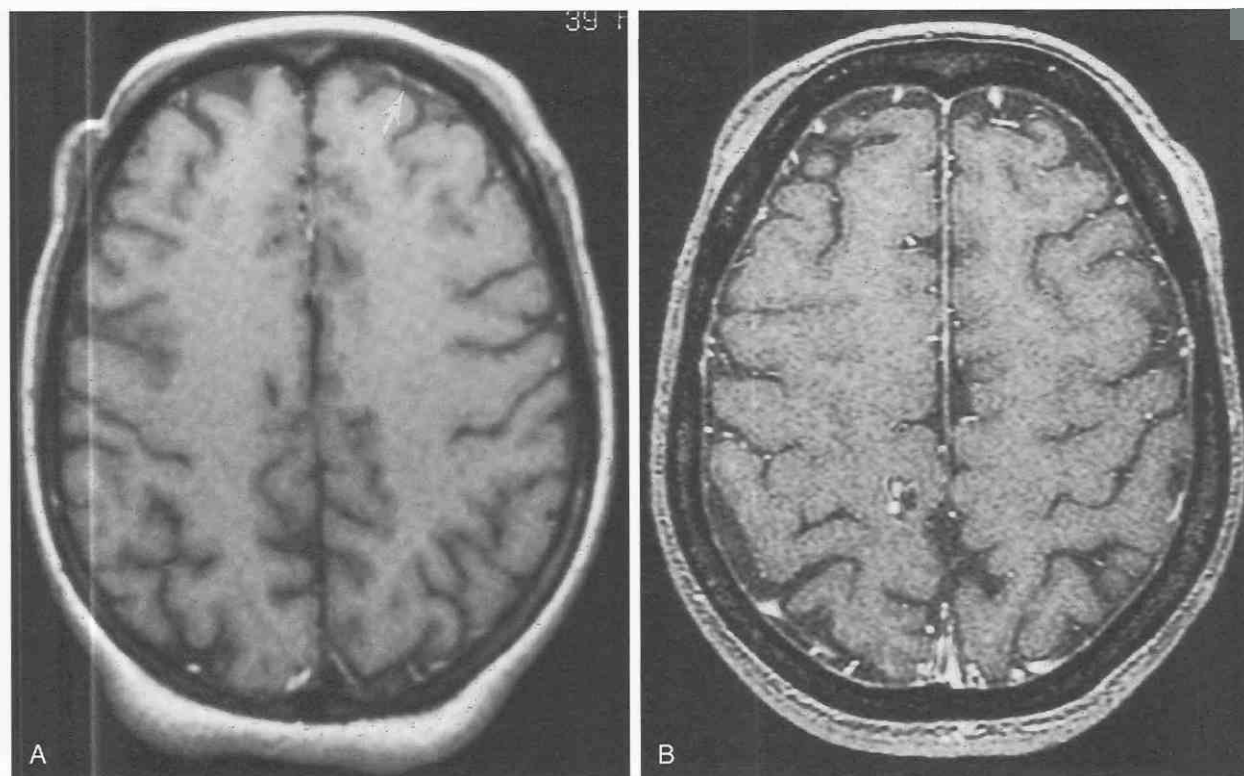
Effects of and pulse sequence on conspicuity of normal meningeal enhancement. *A*, Axial T1-weighted spin-echo image in another patient shows faint, short segment meningeal enhancement (*arrow*). *B*, Axial, spoiled-gradient, recalled-echo image in the same patient shows thin, continuous enhancement in a dura/arachnoid pattern. (From Meltzer CC, Fukui MB, Kanal E, Smirniotopoulos JG: MR imaging of the meninges: Part 1. Normal anatomic features and nonneoplastic disease. *Radiology* 201:297-308, 1996.)
